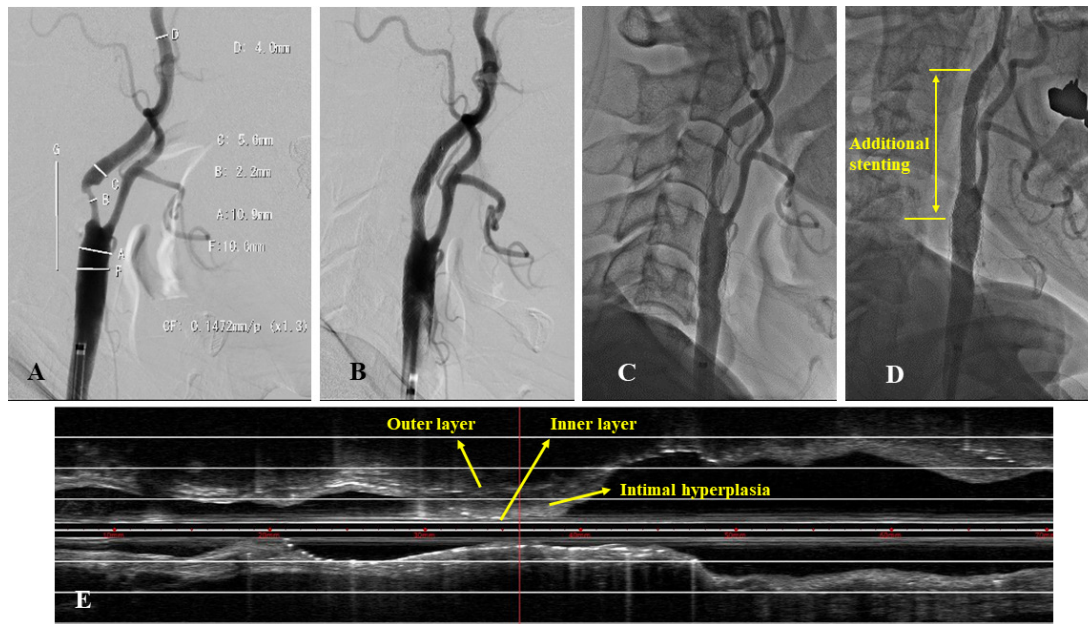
Case of restenosis 3 in figure 1. An adult patient presenting with symptomatic minor stroke underwent carotid artery stenting (CAS) using the CASPER stent (10–30 mm) for 75% stenosis of soft plaque (A). Angiography immediately after CAS showing good patency of the CASPER stent (B). Follow-up angiography after 6 months showing severe restenosis (C). Stent placement was performed with a precise stent (10–40 mm) (Johnson & Johnson, New Brunswick, NJ, USA) (between the yellow lines) for restenosis (D). Intravascular ultrasound (IVUS) after 6 months showing that the inner and the outer layers of the stent are dissociated due to intimal hyperplasia, and the inner layer is partially deformed (E).
